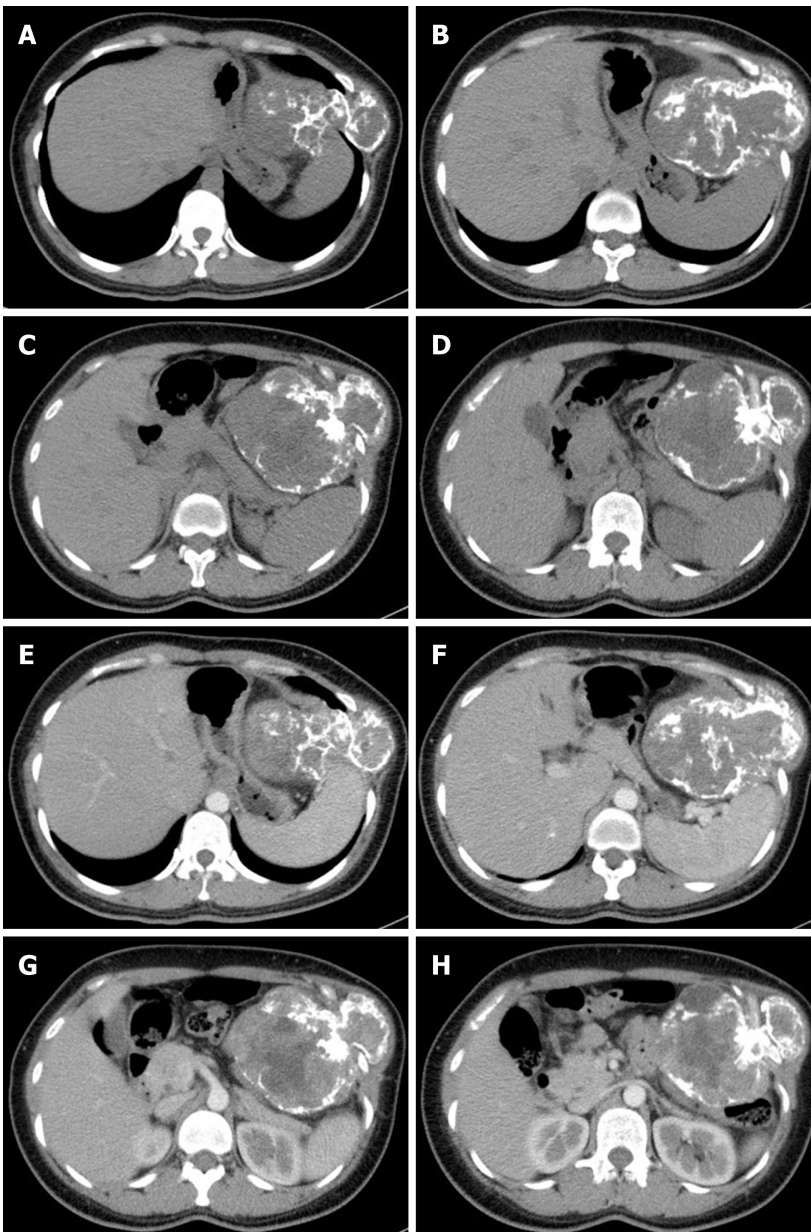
Enhanced chest and abdominal computed tomography revealed the rib mass. A-D: Plain scan; E-H: Enhanced scan.
